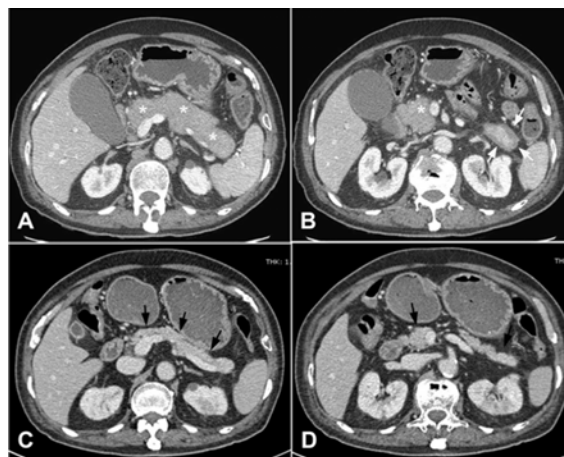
Marked improvement of autoimmune pancreatitis after the treatment with steroids. Axial CT images before the treatment (2A, 2B) show diffusely enlarged pancreas with poor enhancement (* in 2A, 2B) with capsule-like rim at pancreatic tail (white arrows in 2B). Axial CT images after the treatment (2C, 2D) show markedly decreased pancreatic size with normal enhancement and disappearance of capsule-like rim (black arrows in 2C, 2D)
